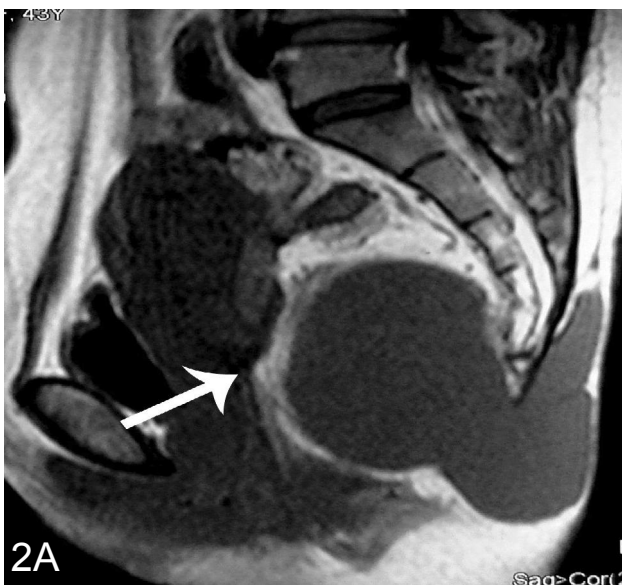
and 2B: Sagittal T1-weighted MR image (Figure 2a) showing hypointense lesion and sagittal T2-weighted MR image (Figure 2b) showing hyperintense lesion, posterior to rectum and anterior to the sacrum and coccyx, extending in the subcutaneous plane behind the coccyx. The lesion is displacing the rectum anteriorly (white arrow). No evidence of communication with the thecal sac.
